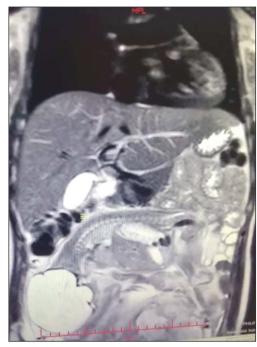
Magnetic resonance imaging coronal section of abdominal pregnancy: presence of oligohydramnios with longitudinally extending fetus.
